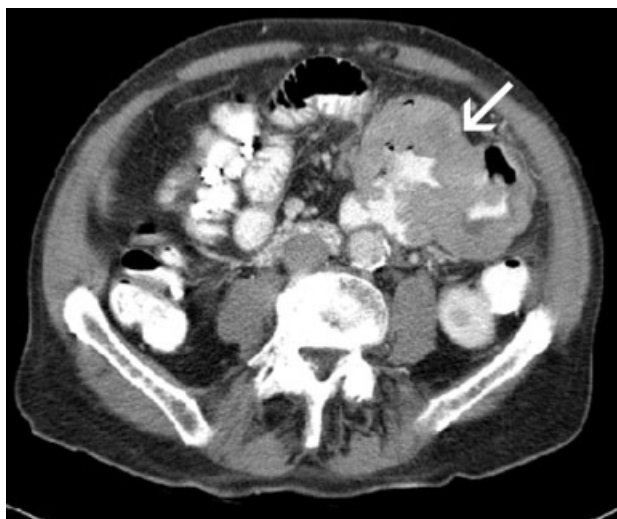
Computed tomography scan of a 78-year-old patient with a 7 × 11-cm highly malignant gastrointestinal stromal tumour of the proximal jejunum (arrow), closely related to but not infiltrating the mesentery of the transverse colon. The main difficulty in the operation was dissecting the tumour away from the superior mesenteric vessels
